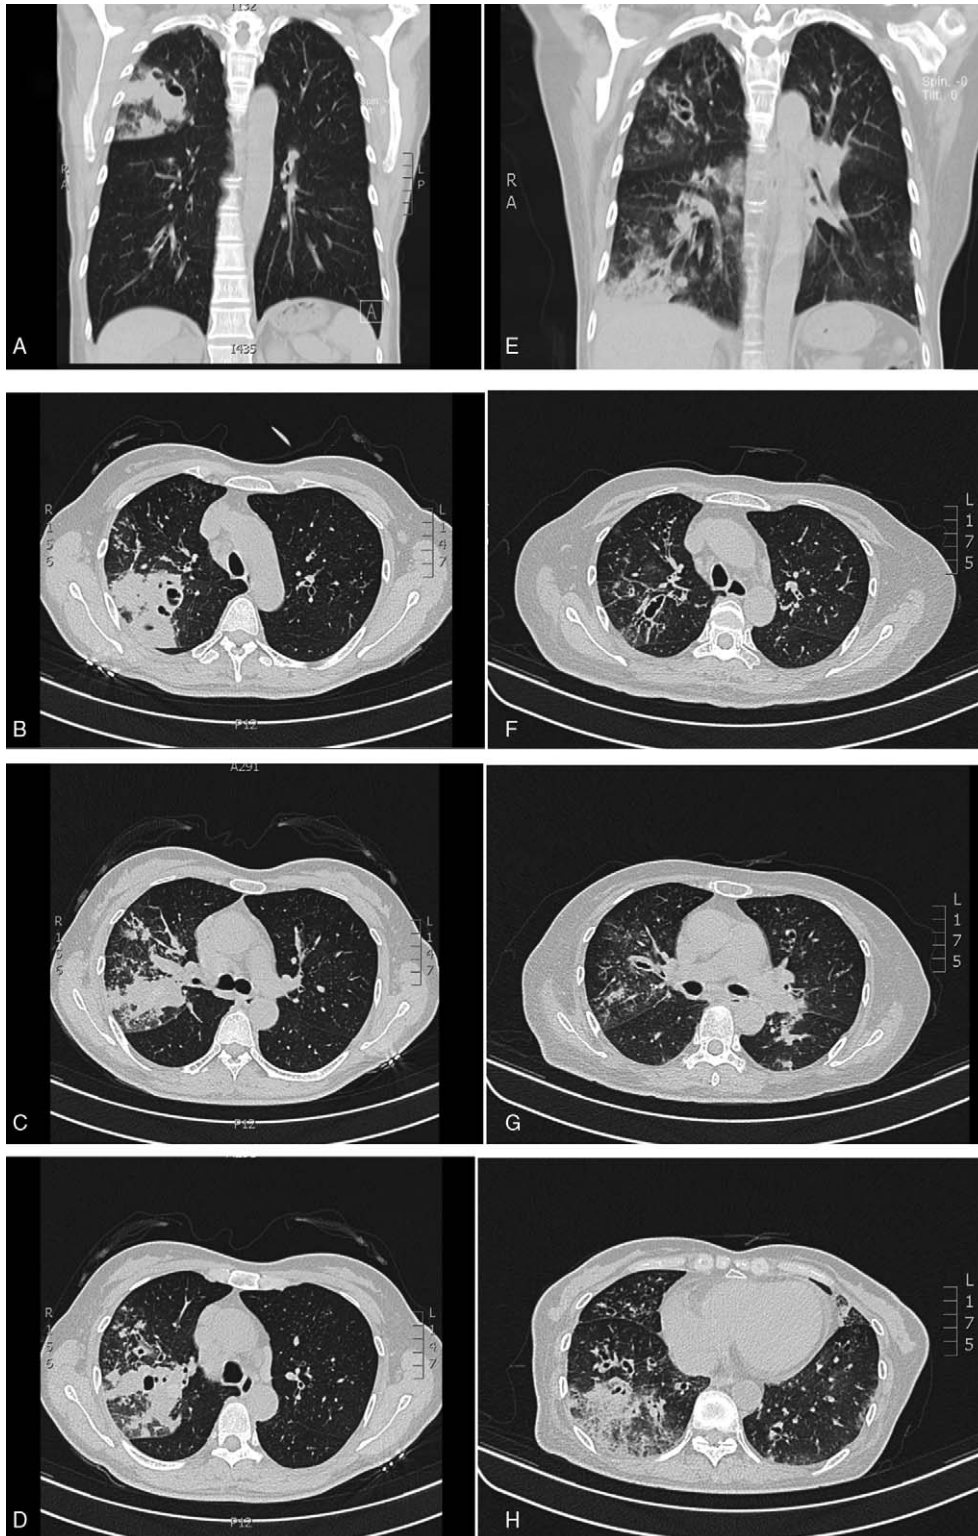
(A–D) Chest computed tomography (CT) findings on the day of admission. (E–H) Chest CT findings at follow-up after 6 weeks of itraconazole therapy for *Aspergillus fumigatus* infection.
